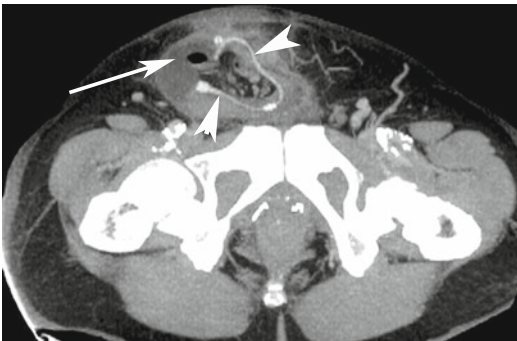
Fifty-nine-year-old patient with artificial urethral sphincter placed post-prostatectomy for urinary incontinence. The patient presented with fever and pain 3 weeks after placement of the device. Axial CT image shows the pump and tubing in the right groin area (*white arrowheads*). There is an abscess (*arrow*) which has developed around the pump and tubing. On ultrasound imaging (not shown), this appeared as a heterogeneous mass and, without appropriate history, could not be diagnosed until CT was performed on follow-up
